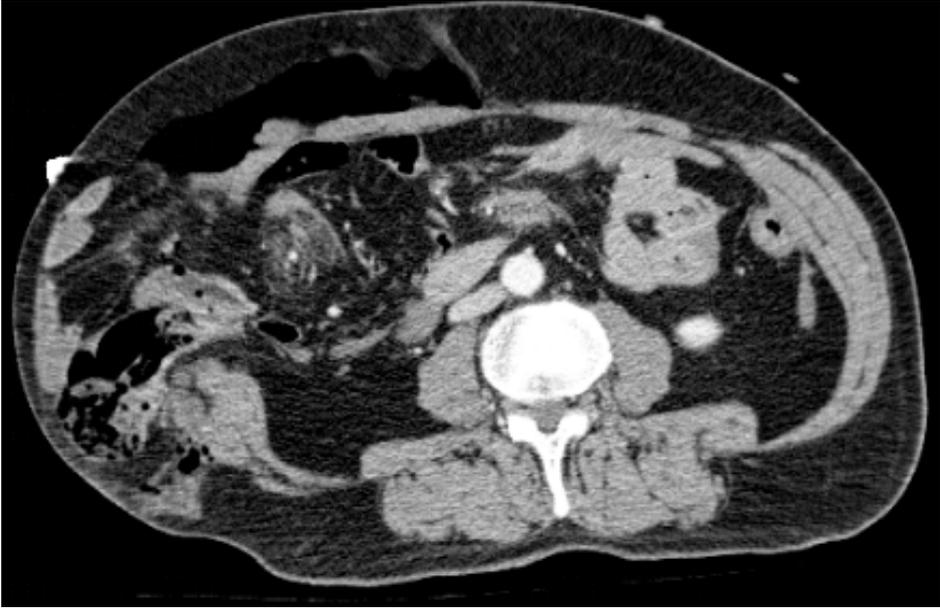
Preoperative abdominal CT scan demonstrating three ruptured muscle layers on the right side
